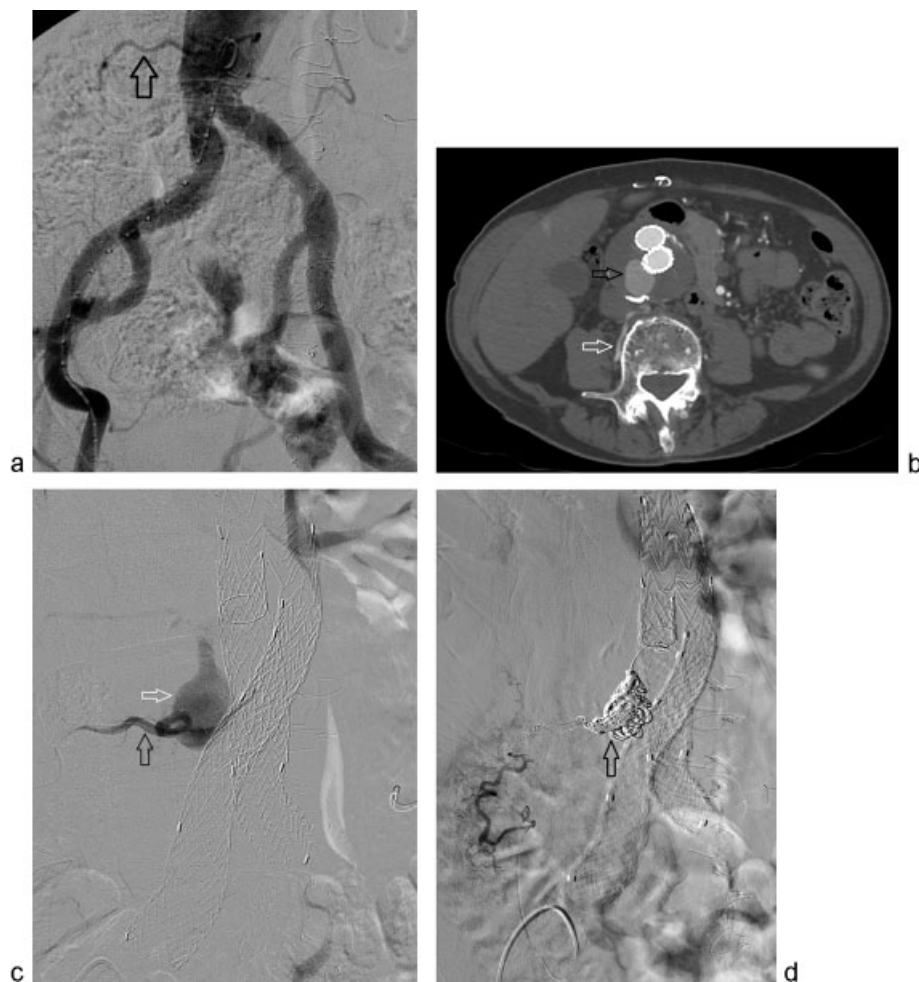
Pre-EVAR planning angiogram (a) demonstrates a patent right lumbar artery (arrow). Postoperative year-4 surveillance CT angiogram (b) shows a patent right lumbar artery (white arrow) and type 2 endoleak (black arrow) with significant growth of the aneurysm sac. Selective right lumbar angiogram (black arrow) (c) shows filling of the aneurysm sac (white arrow). Completion angiogram (d) following successful coil embolization (arrow) of the aneurysm sac and right lumbar artery.
